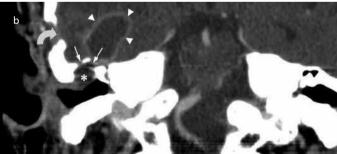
a, b. Axial contrast-enhanced CT image of the brain (a) and coronal contrast-enhanced CT image of the temporal bone (b) showing an otogenic intracranial abscess of the right temporal lobe. The abscess has an enhanced wall (arrowheads) and is surrounded by marked vasogenic edema obliterating the cortical sulci and the temporal horn of the right lateral ventricle. The underlying cholesteatoma (asterisk) has caused bony erosions (arrows) toward the middle cranial fossa. Note that the temporal bone CT (b) was performed after initial punction of the abscess (post-trepanation defect marked with curved arrow), which alone, without curing the underlying COM with cholesteatoma, has been insufficient as a surgical treatment. CT: computed tomography
